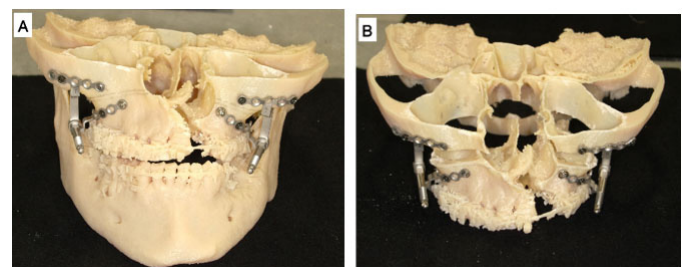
Photograph of a 3D model from preoperative CT images showing positioned distractor foot plates and rods (A, B).
